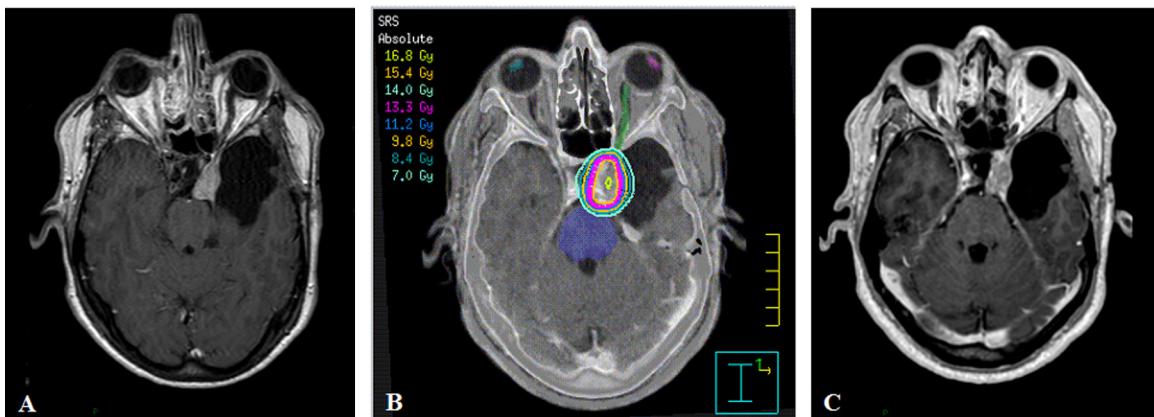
Recurrent benign meningioma in a 47 years old male previously treated with partial surgery. (A) MRI in axial view of the residual meningioma after surgery at the level of the left cavernous sinus. (B) Axial view of the treatment plan showing the isodose distribution of SRS to a dose of 14Gy (prescribed to the 95% isodose). (C) MRI in axial view 3 years after completion of SRS.
